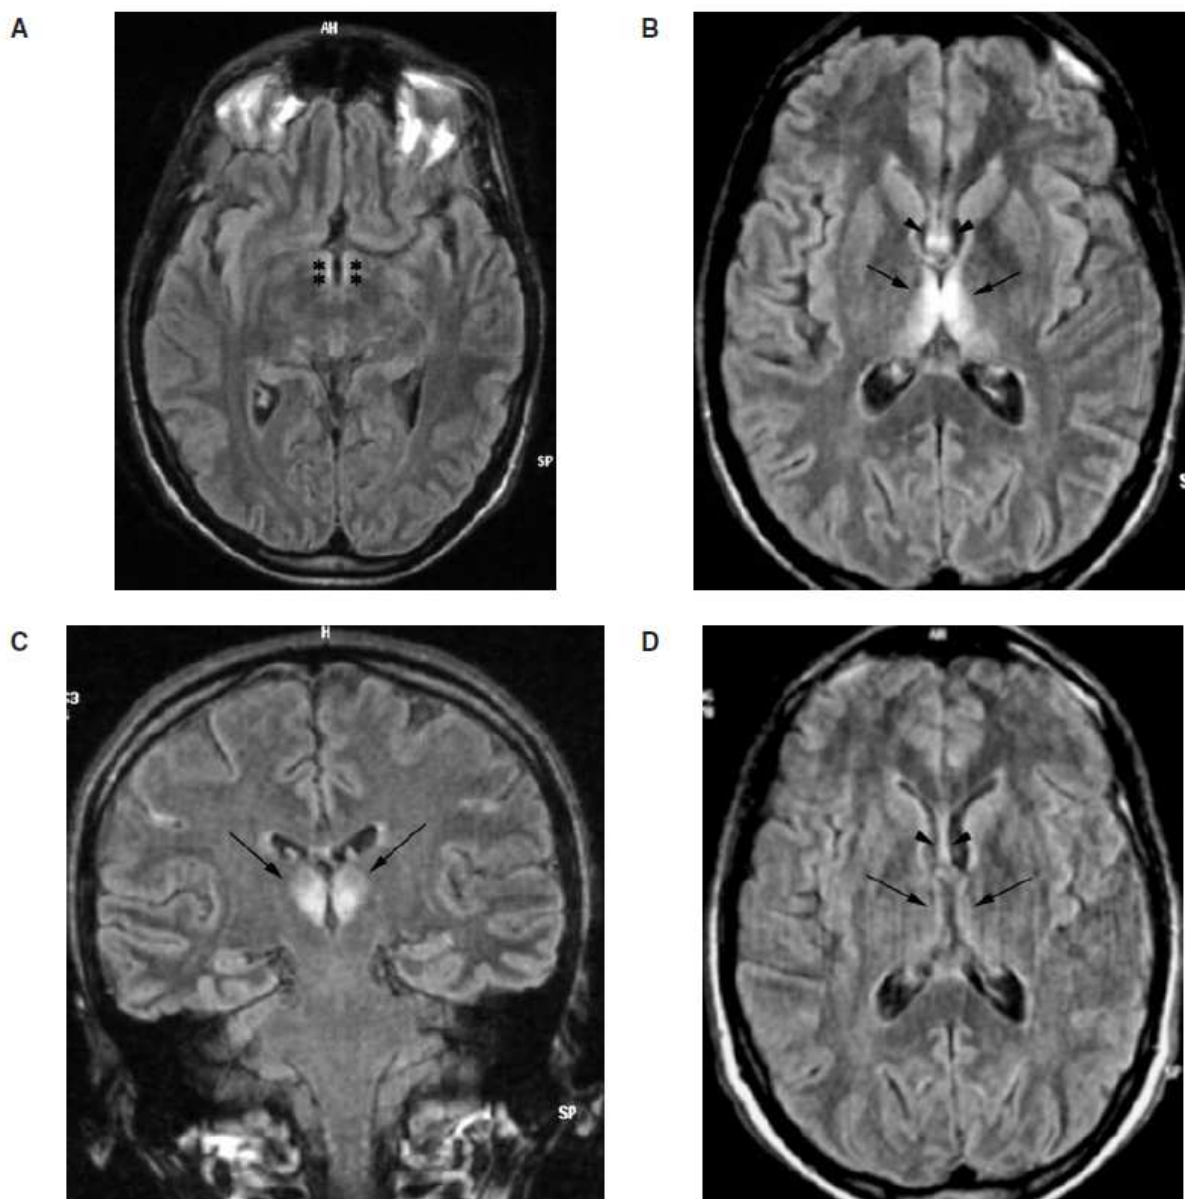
'Images from axial and coronal FLAIR sequence of the WK subject. Seven-day MRI study demonstrates signal abnormalities of the mammillary bodies (A) (stars), the medial aspect of the thalami (B, C) (arrows) and the fornix (B) (arrowheads). Five months later signal changes have almost completely disappeared (D) (arrows and arrowheads)' - With the permission of M. Caulo, Fig 2 from (Caulo, Van Hecke et al. 2005).
